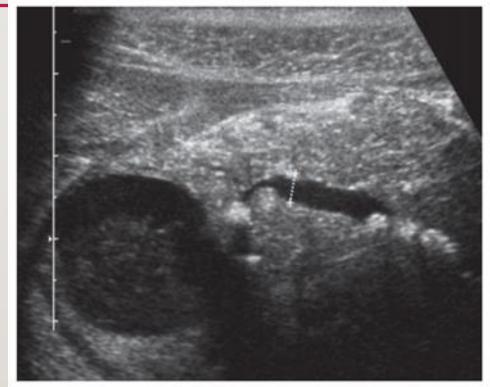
Transabdominal ultrasound showing typical changes of chronic pancreatitis. Note the multiple intrapancreatic calcifications and the dilated pancreatic duct. A large pseudocyst is also present in the region of the head of the pancreas.
